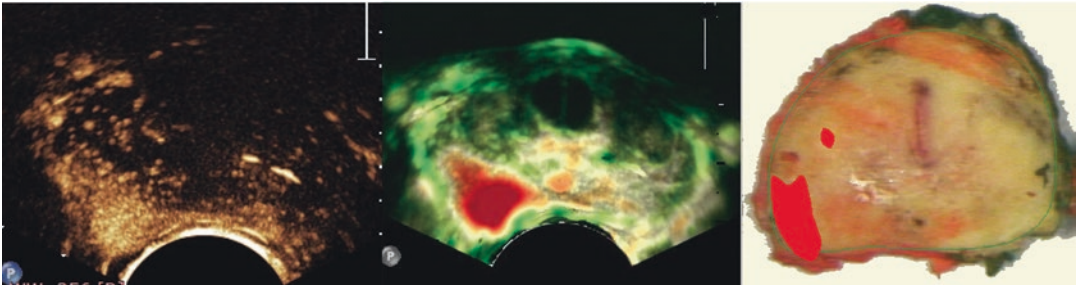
Dynamic contrast-enhanced ultrasound (DCE-US) and parametric map of the prostate. *Left:* DCE-US of the prostate showing strong early enhancement suspicious for prostate cancer (PCa) in the right peripheral zone (lower left side in the image). *Middle:* contrast ultrasound dispersion imaging (CUDI) map
